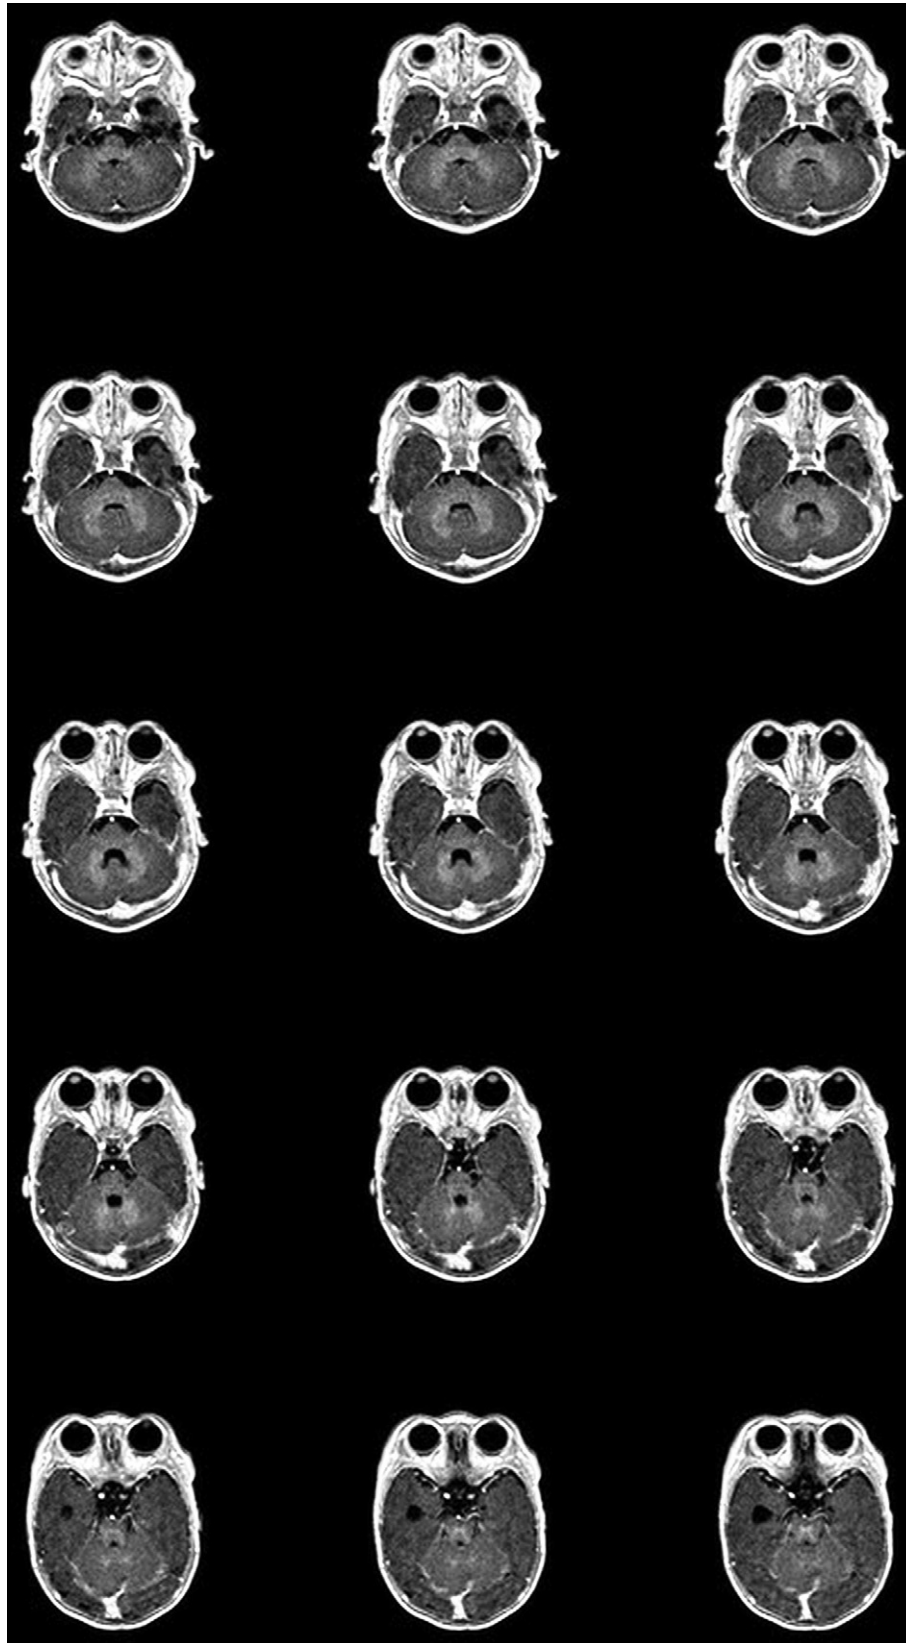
Postnatal magnetic resonance imaging revealed atrophic bilateral optic nerves and optic chiasma (transverse view, T1-weighted image).
